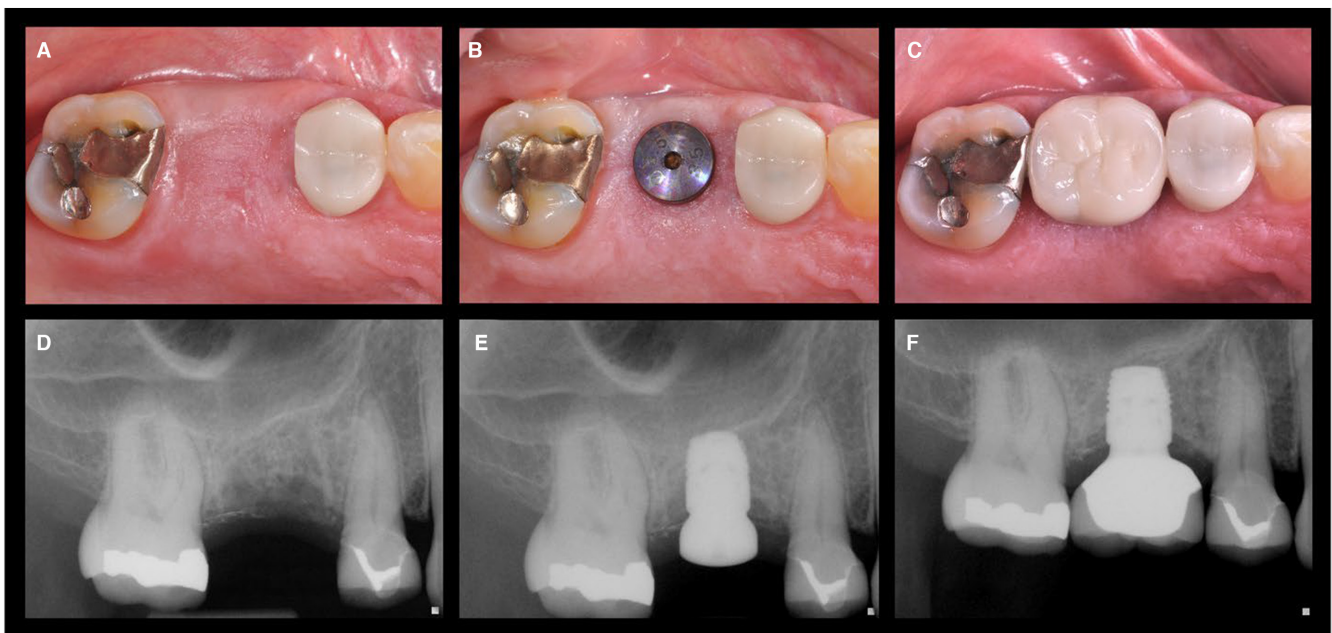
Sequence of a case of tooth replacement therapy of a maxillary right first molar with an implant-supported fixed dental prosthesis involving the use of a short implant to avoid maxillary sinus floor augmentation. The upper row shows the intraoral aspect of the site at baseline (A), 2 months after implant placement (B), and 1 year after the delivery of the final prosthesis (C). The lower row displays a periapical radiographic sequence of the area at baseline (D), 2 months after implant placement (E), and 1 year after the delivery of the final prosthesis (F). (Adapted with permission from Avila-Ortiz et al.¹).
